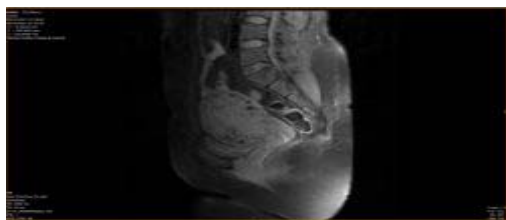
MRI-Invasive Mole
